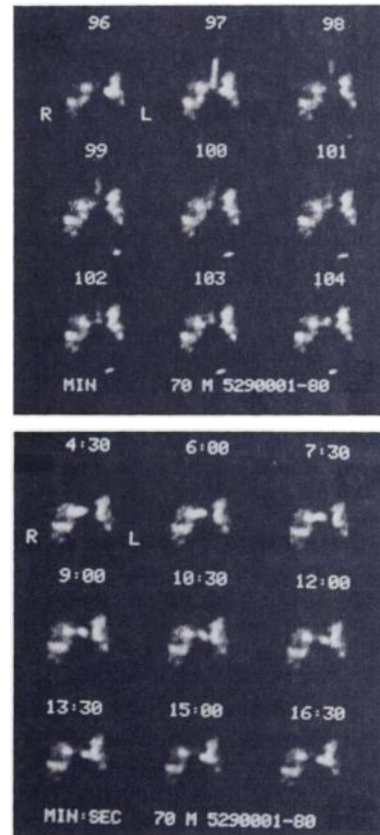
Top: One-min images, starting from indicated times after radioaerosol inhalation (earlier phase), in 70-yr-old man with pulmonary emphysema and history of recurrent infections. Note shot of radioactivity gradually migrating from right bronchus into left. (Right lung is toward viewer's left.) Below left lung is swallowed radioactivity in stomach. Here image color code was normalized to peak activity detected. In actual radioaerosol inhalation lung cinescintigraphy, each 10-sec frame is transformed to cine mode to allow visual evaluation of dynamic mucus transportation and lung clearance. Bottom: Still images (later phase) from same patient. Cough occurred at 97 min, and radioactivity was pushed cephalad. At 98 min some radioactivity was swallowed into stomach where radioactivity again increased. Shuttle motions of radioactivity persisted between right and left bronchi after coughing subsided.
